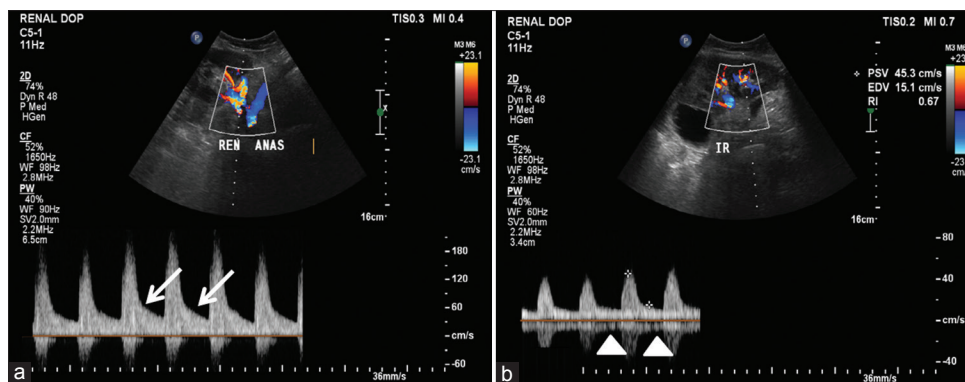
Follow-up renal Doppler performed 45 days later revealed the normalization of flow pattern in transplanted renal artery (a, at site of anastomosis [arrow]) and intrarenal arteries (b, arrow head)
